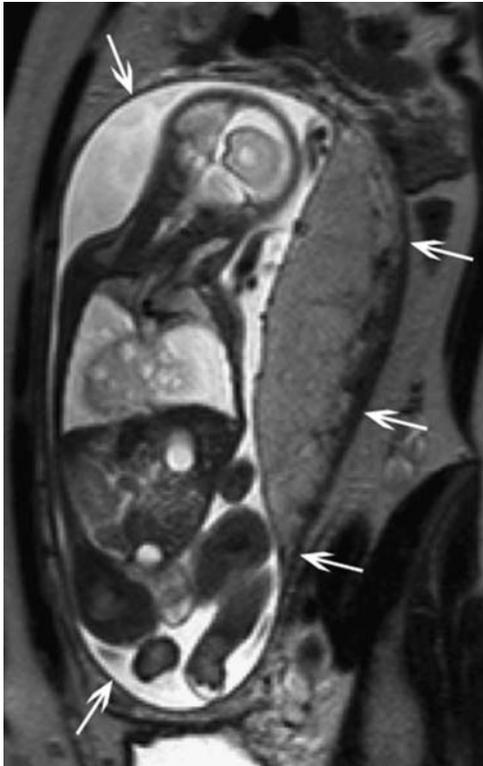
Normal magnetic resonance imaging (MRI) appearance of the placenta. T2-weighted sagittal image allows differentiation of the normal hypointense myometrium (arrows) from the relatively hyperintense placenta (P). With placentation abnormalities, this separation of planes is compromised.
